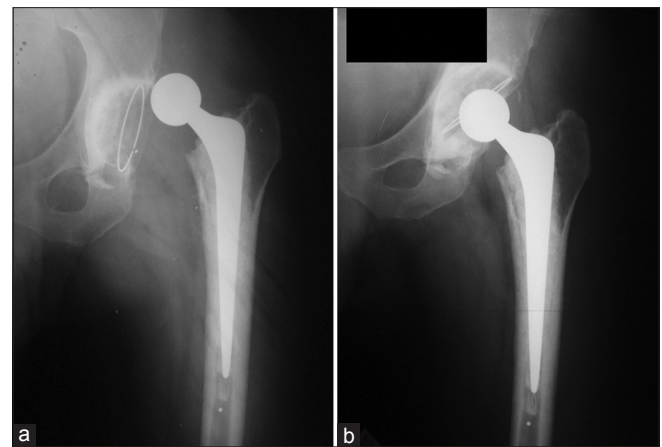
X-ray left hip joint anteroposterior view showing (a) Dislocation in 28 mm head total hip replacement due to lower anteversion of cup with higher abduction angle (b) Revision of cemented cup with cemented cup
